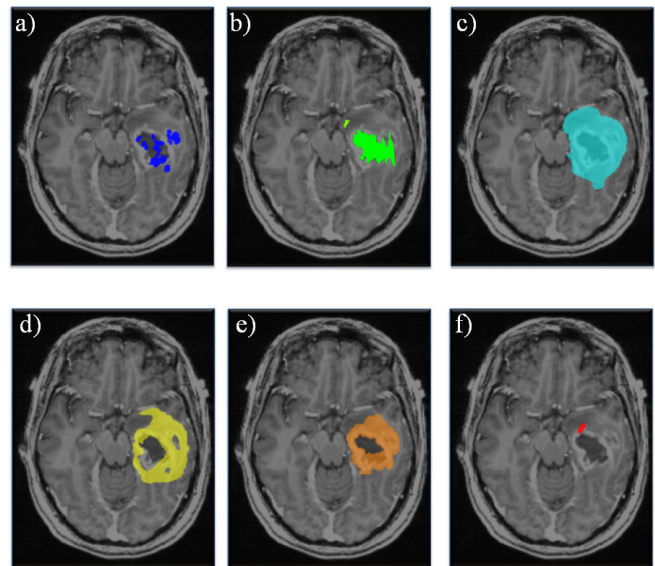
Radiologist generated Segmentations: a) SWI, b) Necrosis, c) FLAIR, d) Diffusion restriction, e) Enhancement, f) rCBV have been superimposed on T1-post contrast image.
